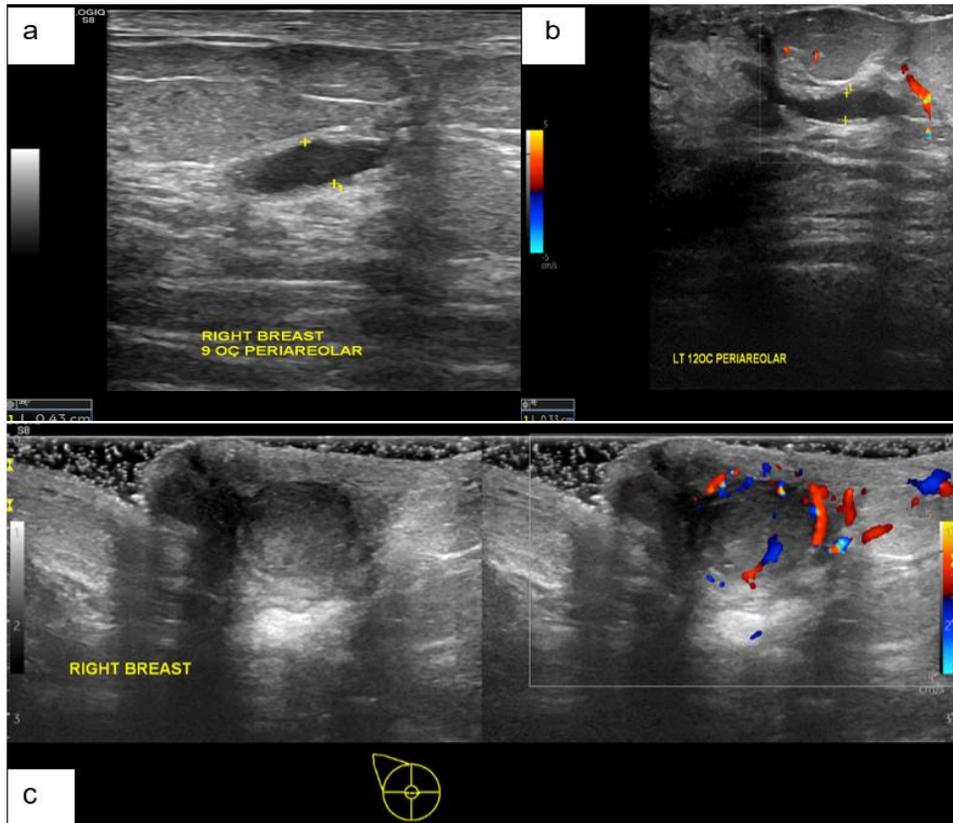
Breast Ultrasound Images; (a) Right breast: 9 o'clock distended duct; (b) Left breast: 12 o'clock distended duct; (c) Right breast abscess
